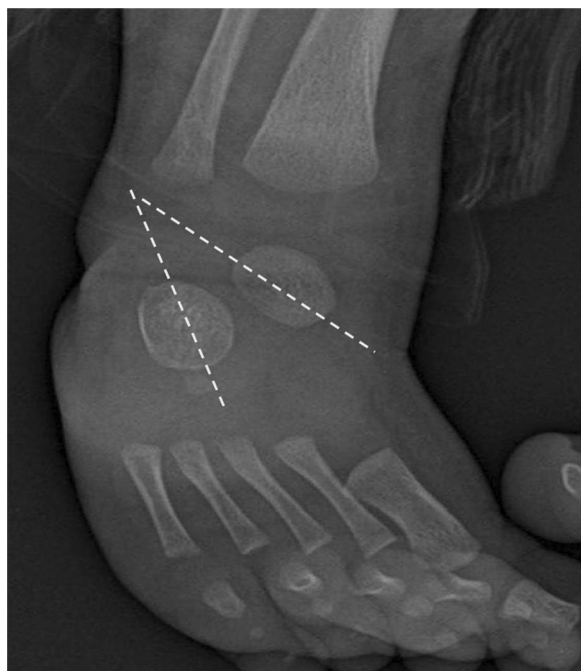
Plain X-ray AP view of the of the left foot for a 23-day-old male baby, presenting with vertical talus, showing increased talocalcaneal angle
